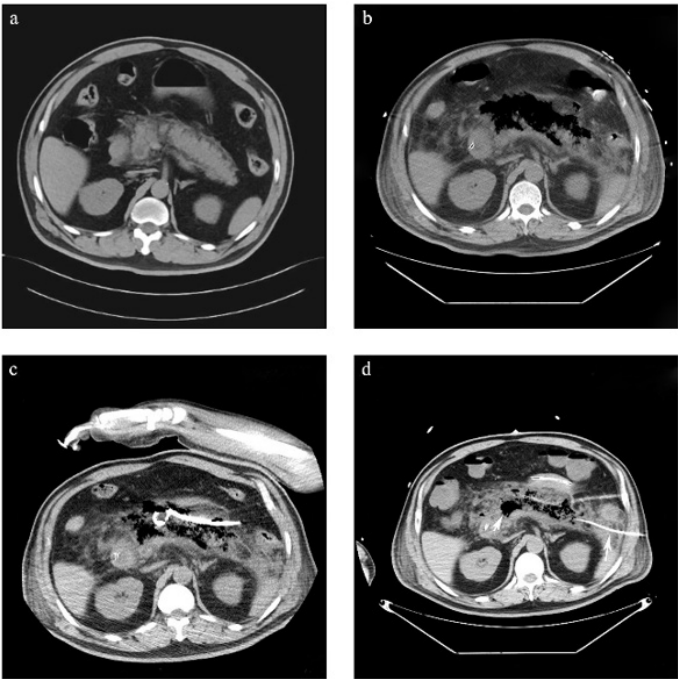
(a) CT showed pancreatic edema and inflammation. (b) The CT scan revealed a significant presence of gas surrounding the pancreas, measuring approximately 153.54mm*38.97mm. (c) The CT scan revealed that percutaneous catheterization was performed on the patient. (d) The CT scan revealed decreased peripancreatic gas, and a simultaneous second
